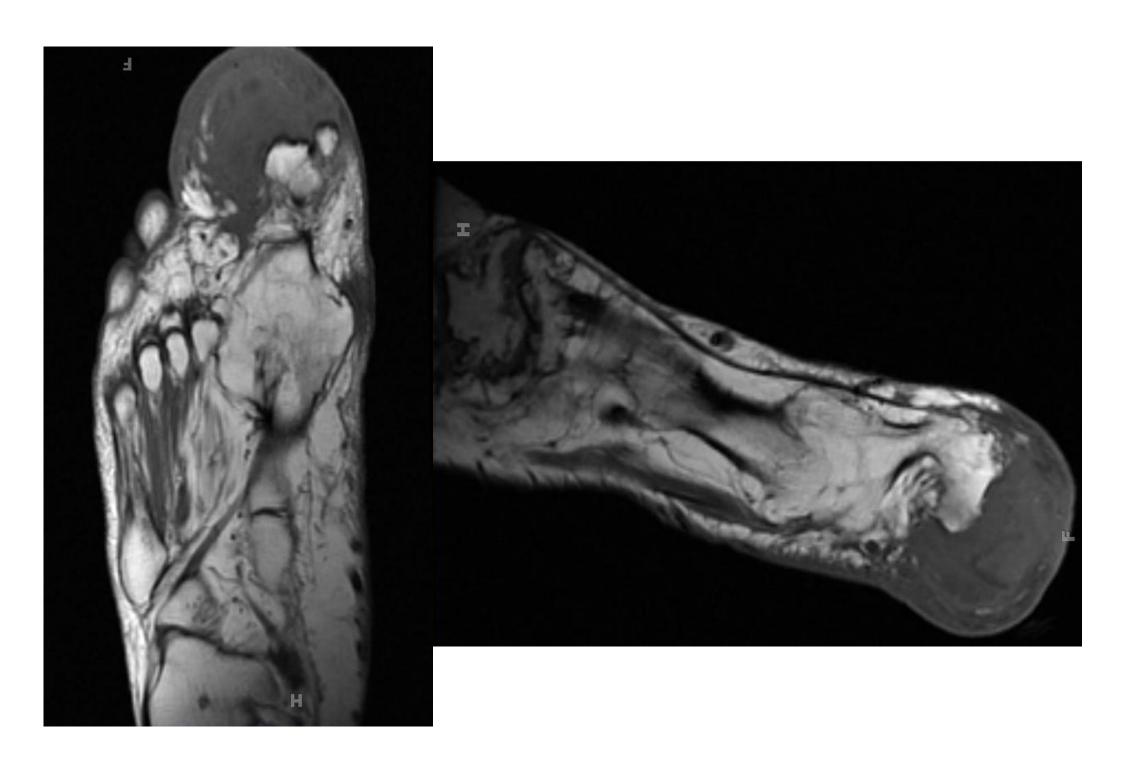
Advanced magnetic resonance imaging; showing no boney or soft tissue infectious processes
